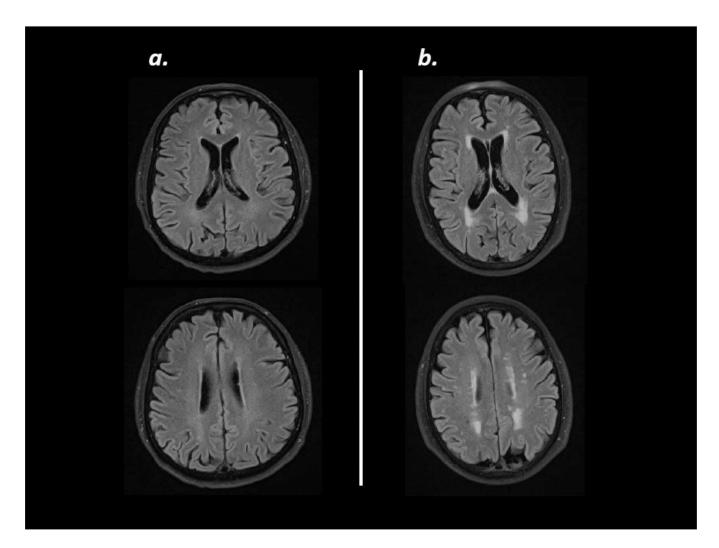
Example MRIs (5mm axial FLAIR) showing the typical range of white matter disease in this study. The scan on the left (*a*) shows minimal white matter disease corresponding to a combined Fazekas score of 1 and the scan on the right (*b*) shows a moderate amount of white matter disease corresponding to a combined score of 3.
